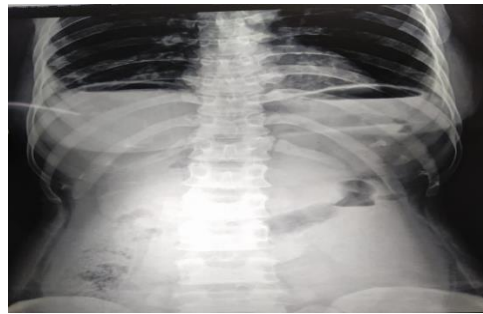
X-ray showing free gas under domes of diaphragm to sigmoid volvulus
